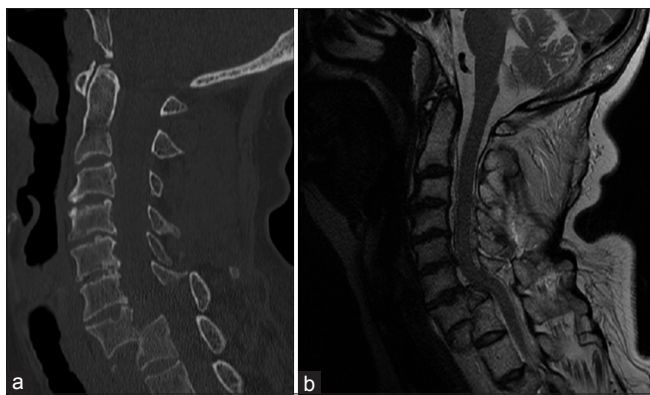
Patient 1 – (a) Computed tomography C spine, (b) magnetic resonance imaging C spine
